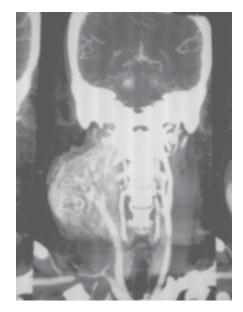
CT carotid angiogram showing massive carotid body tumour. Digital subtraction angiography shows the normal internal carotid and vertebral arteries on the ipsilateral side and normal neck vessels on the contralateral side.
